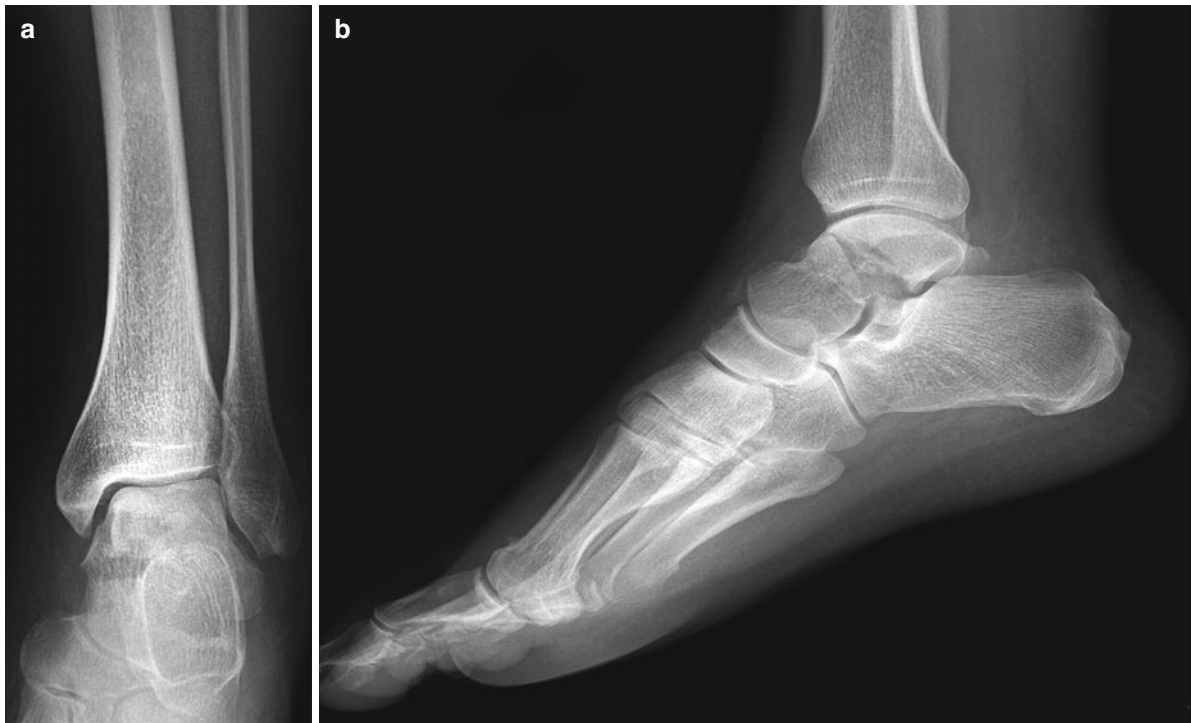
A patient, who fell down from a 6-m-high roof, was injured with a talus fracture type III, according to Marti and Weber, with dislocations in the talonavicular (*arrow* in e) and subtalar joints (*arrow* in d) seen in the X-rays (a, b) and preoperative CT scans (c, d, e). Closed reduction and tibiometatarsal
